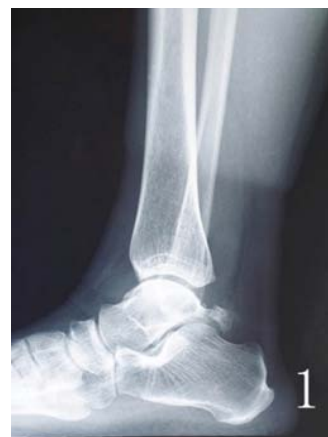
Lateral radiograph showing free bone behind the talus.
